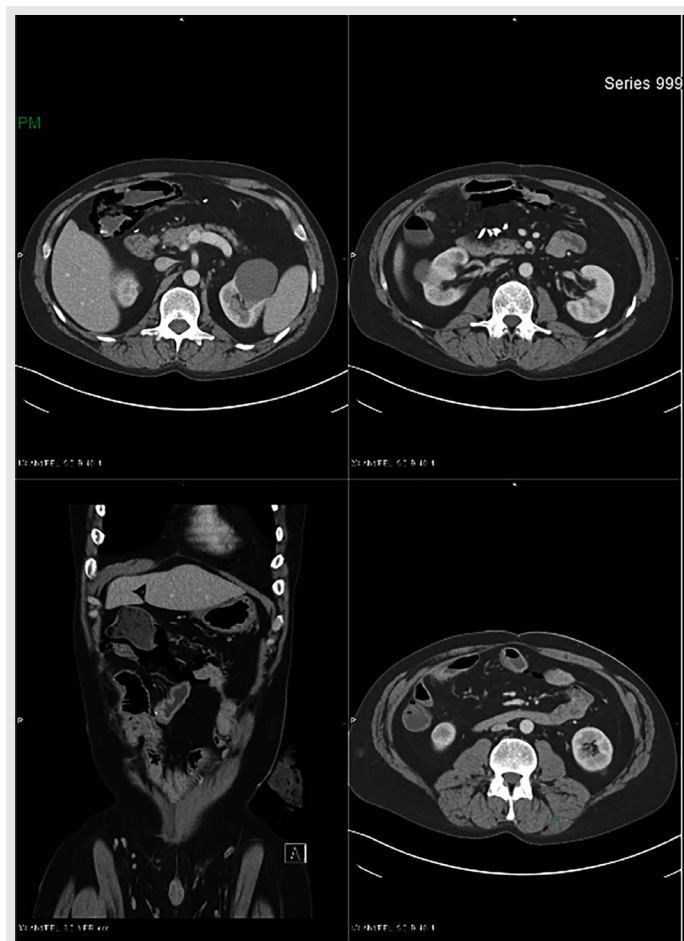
Computed tomography with contrast reveals extensive bowel pneumatosis, especially in the right upper quadrant.
